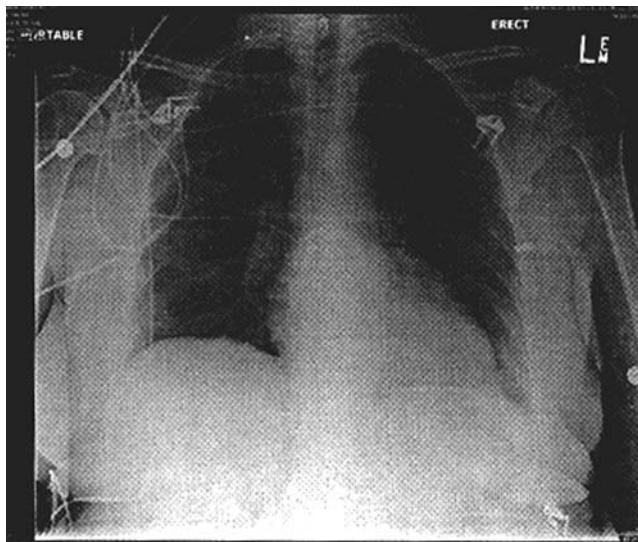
Normal chest radiograph at admission of a 63-year-old woman with babesiosis
